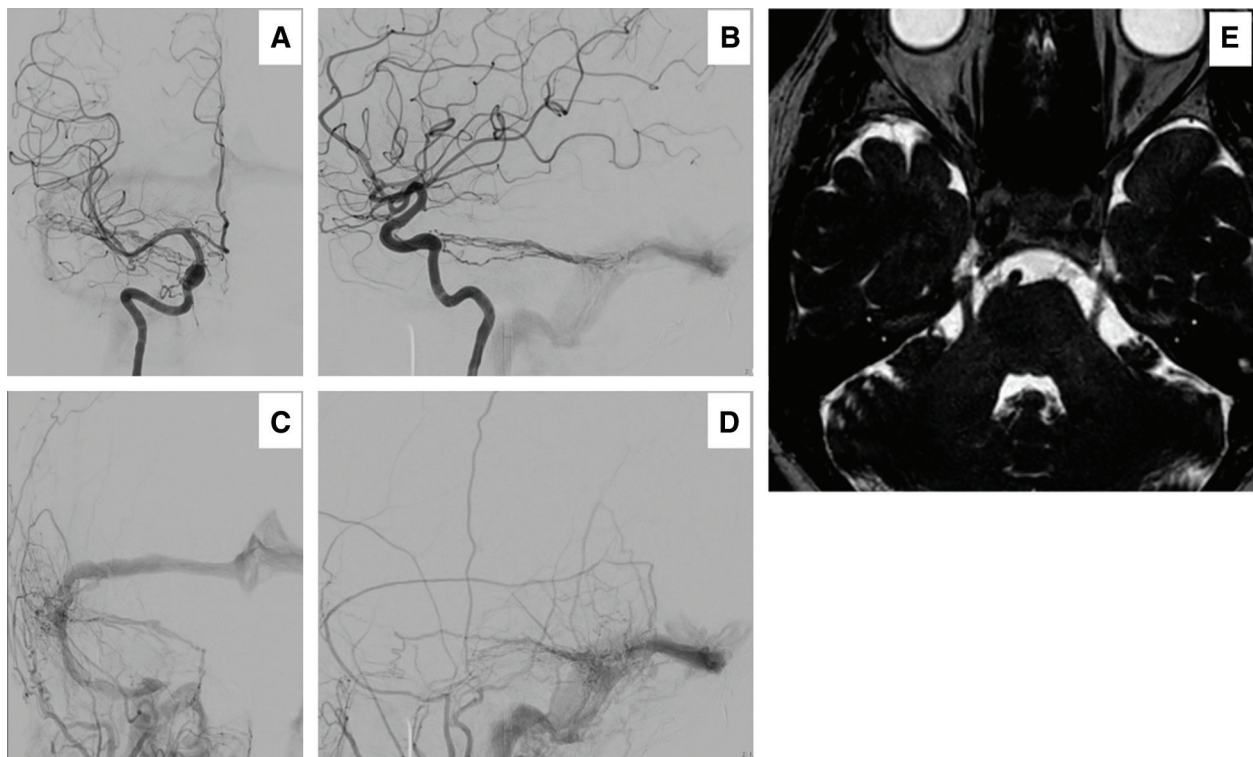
The right internal carotid (A and B) and the right external carotid (C and D) angiograms 3 months after the first treatment showing the recurrence of the DAVF. MRI FIESTA image (E) shows no
